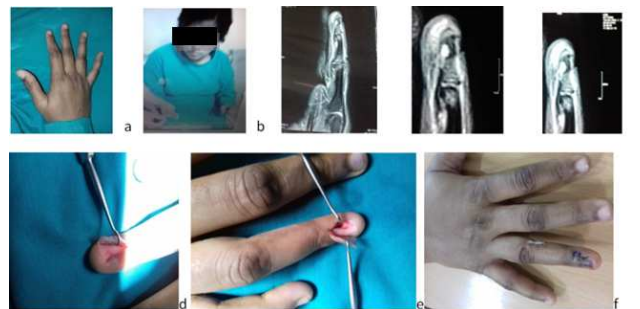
a. Pre operative image 22yrsfemale at right ring finger at sub ungualregion at radial border. b. pin point tenderness at lesional area c. MRI atring fingershowingwell defined mass beneath the nail plate. d. Per operative appearance. e. after removal of glomus tumor. f. post operative appearance at 10 days.
